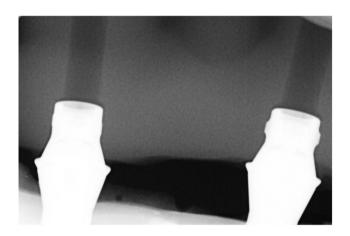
Periapical radiograph indicating accurate fit
